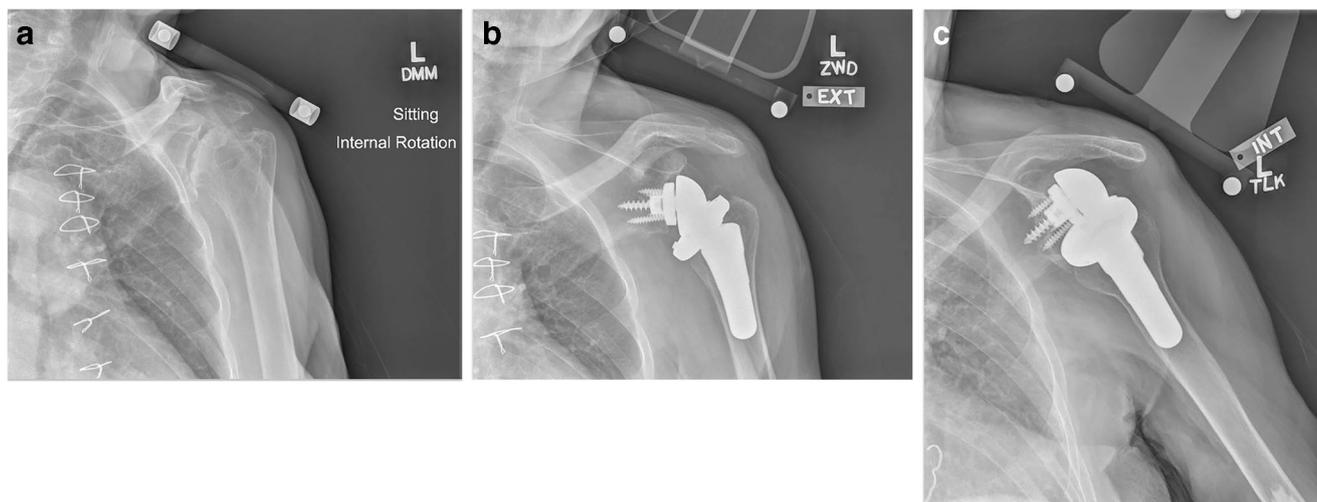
Complication example: a Pre-operative, b initial post-operative, and c final follow-up X-rays of a 78-year-old with glenoid loosening and component displacement at most recent follow up (25 months post-surgery). Patient elected to not undergo revision surgery
